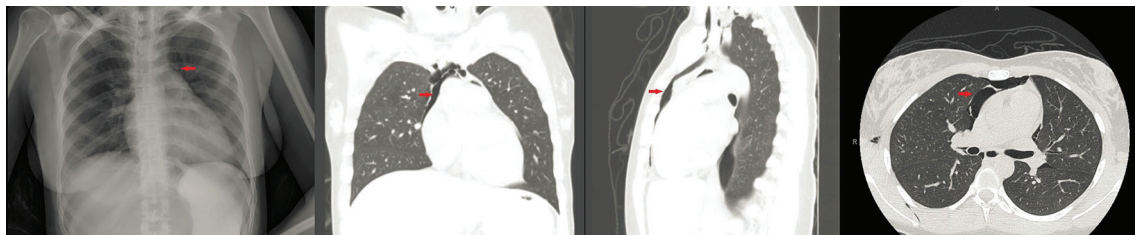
CXR and sagittal and coronal view of chest CT. Red arrow points to pneumomediastinum. Normal lung parenchyma.
